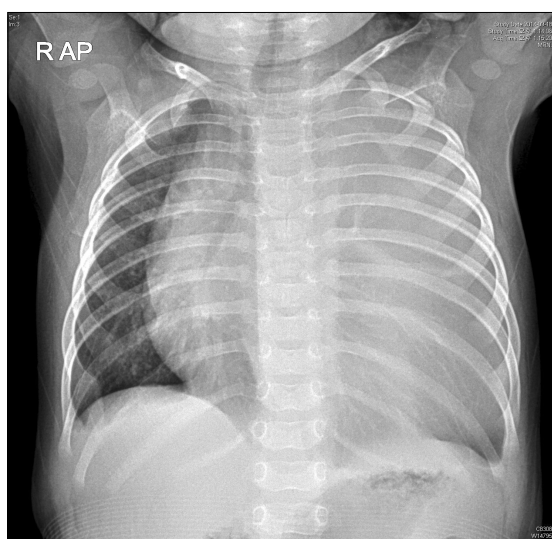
Chest x-ray taken at the first visit.
